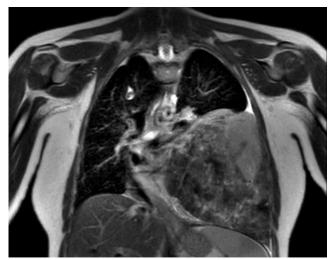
Computed tomogram showing voluminous mass with regular contour, heterogeneous content, compression of neighboring structures and no sign of invasion.
